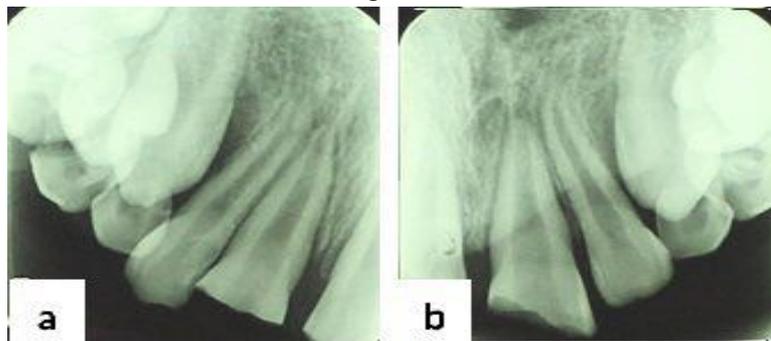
initial radiography of patient after replantation.
